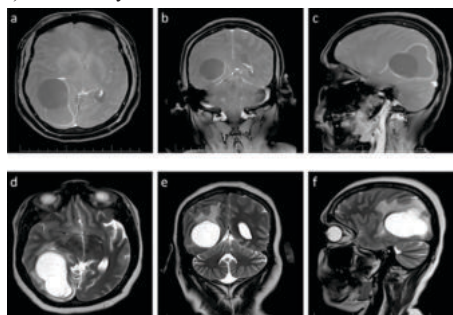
MRI brain showing lesion in right parieto-temporo-occipital region.
